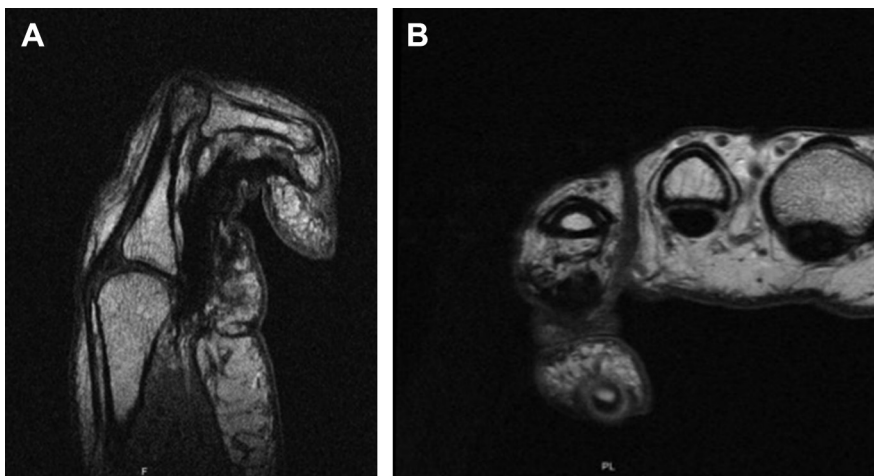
(A) Sagittal and (B) Axial MRI demonstrating bowstringing in the small finger of Patient 3. Note the distance of the flexor tendon away from the volar surface of the proximal phalanx as well as the PIP flexion contracture. (Courtesy of S. Wolfe, MD, New York, NY.)
